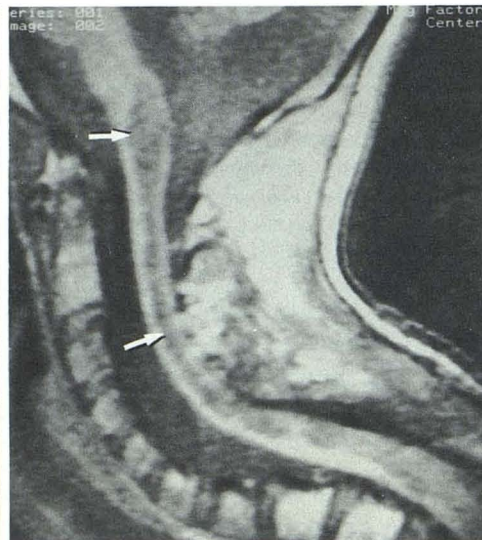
Cervical ependymoma. Focal expansion of cord in 43-year-old woman secondary to indistinctly margined tumor (arrow) is identified in T1-weighted spin-echo image (TR = 350 msec, TE = 20 msec). Signal intensity of tumor is intermediate between normal cord and CSF.
